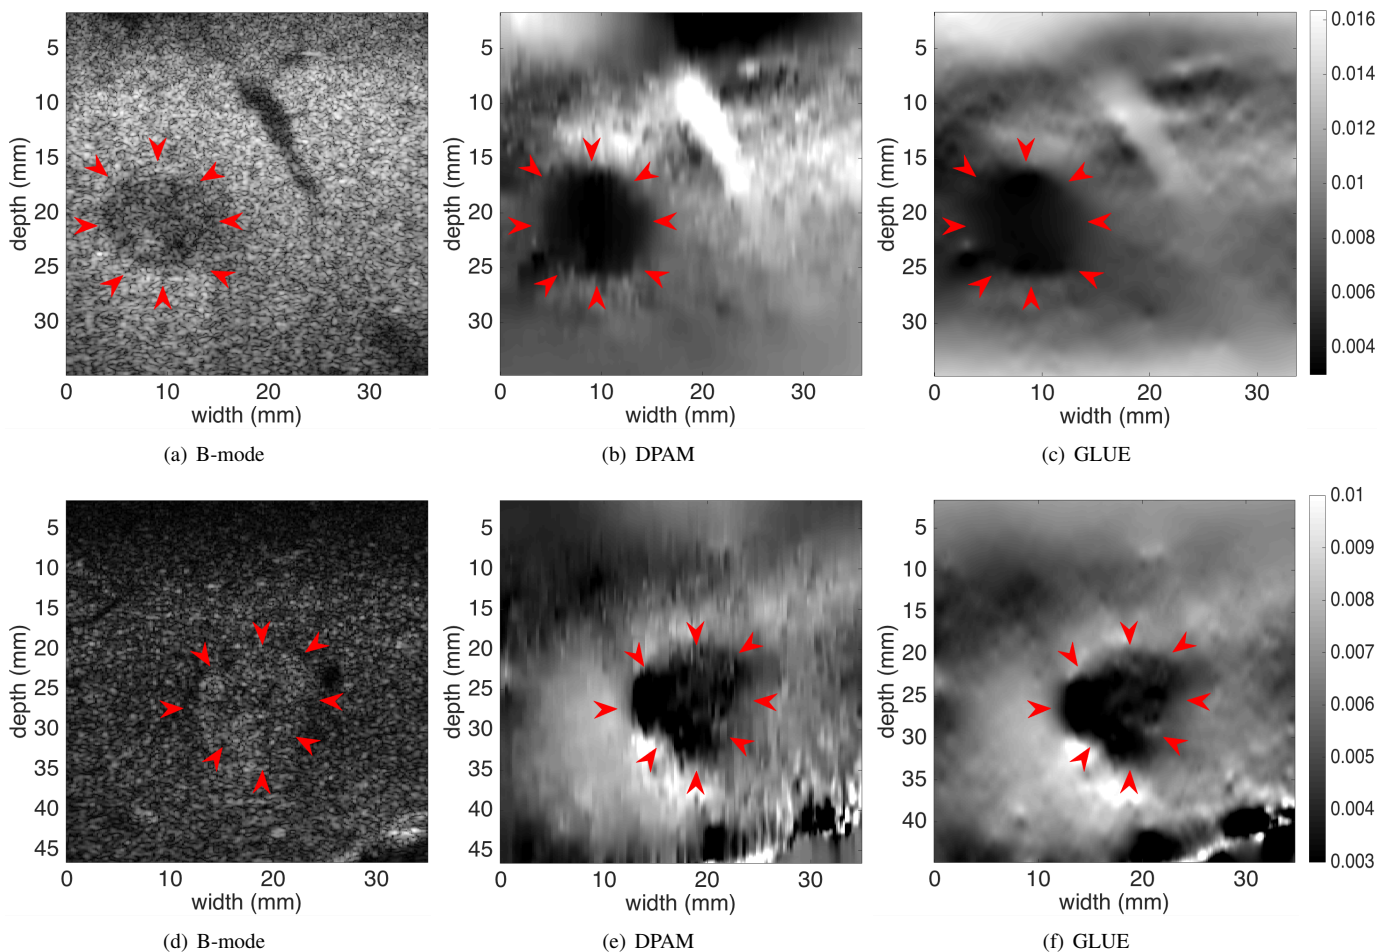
B-mode and strain images of the patient data before ablation. First and second rows respectively correspond to patients 2 and 3. The red arrows point to the tumours. The strain images provide a substantially improved visualization of the tumours compared to the B-mode ultrasound images.
